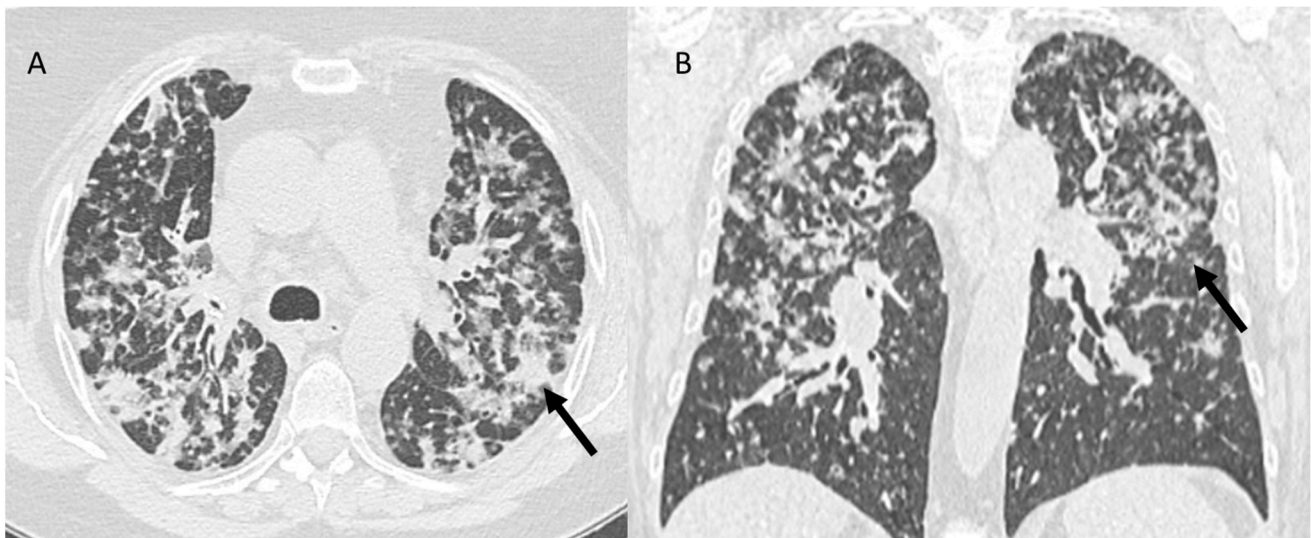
CT assessment ((A): axial plane; (B): coronal plane of PLC in pancreatic cancer patient: irregularly interlobular septal thickening or nodular thickening (arrows).
